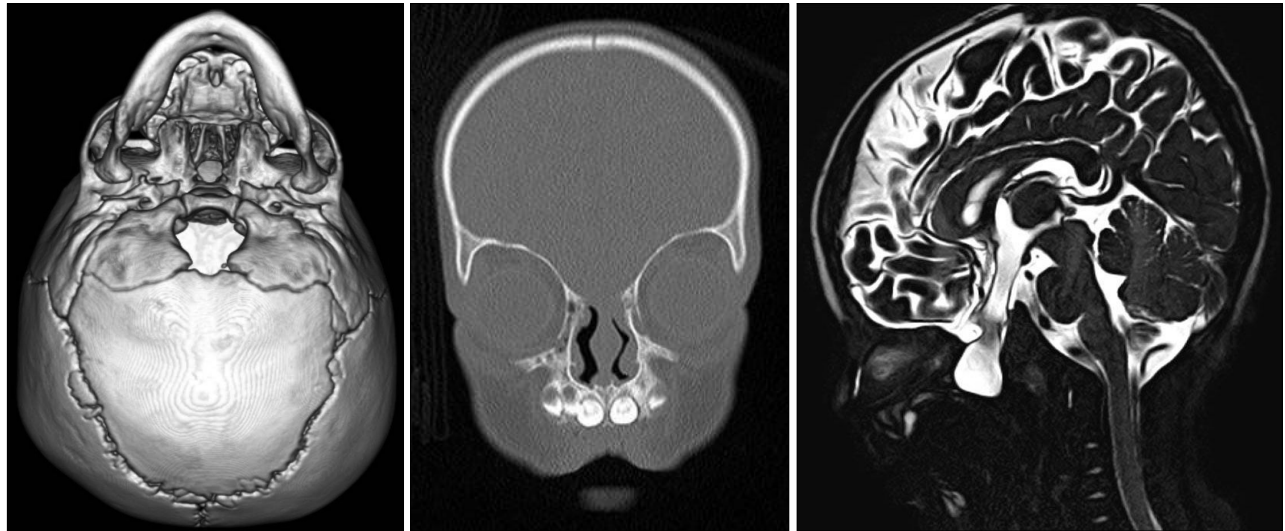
(Left) Inferior view of three-dimensional computed tomography. Note the midline alveolar cleft. (Center, right) Computed tomography and magnetic resonance imaging. The large basal bony defect in sella area with sphenoidal meningoencephalocele was observed.
